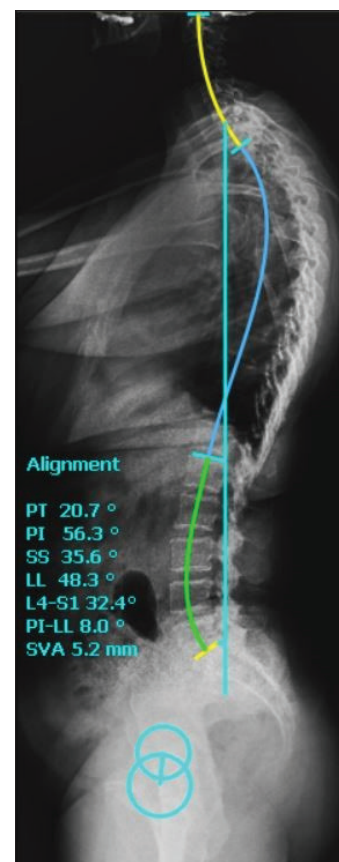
Preoperative lateral X-ray of the patient who underwent short-level fusion.
